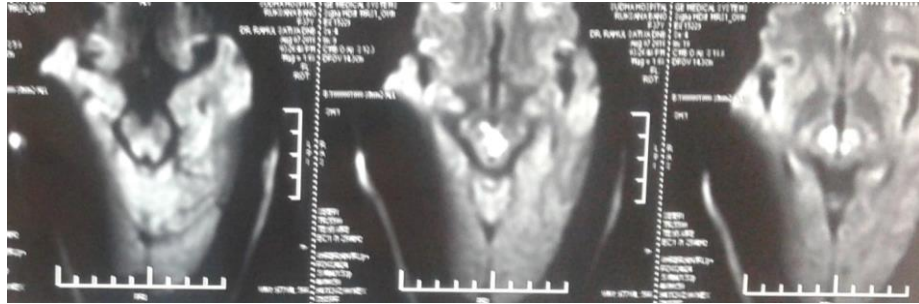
Diffusion weighted imaging of MRI brain (axial sections) showing hyper intensity in bilateral thalami and midbrain.
